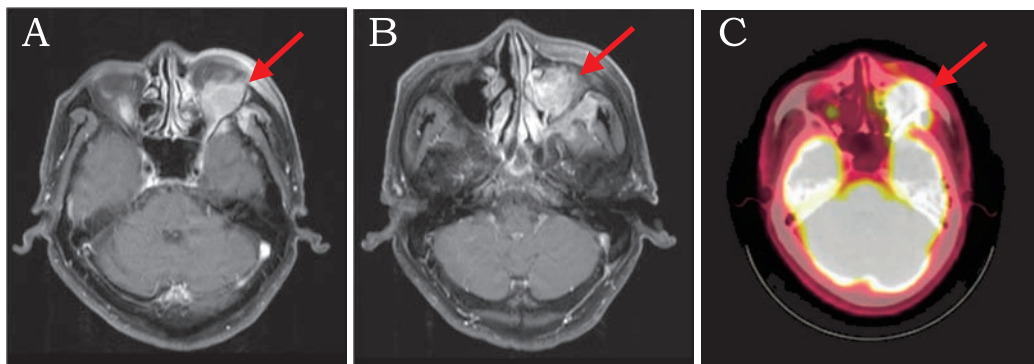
(1A & 1B) Magnetic resonance imaging showing soft tissue mass in the left orbit and maxillary sinus before treatment. (2C) ¹⁸F-fluorodeoxyglucose (¹⁸F-FDG) positron emission tomography showing accumulation of ¹⁸F-FDG in the left orbit and maxilla before treatment.
